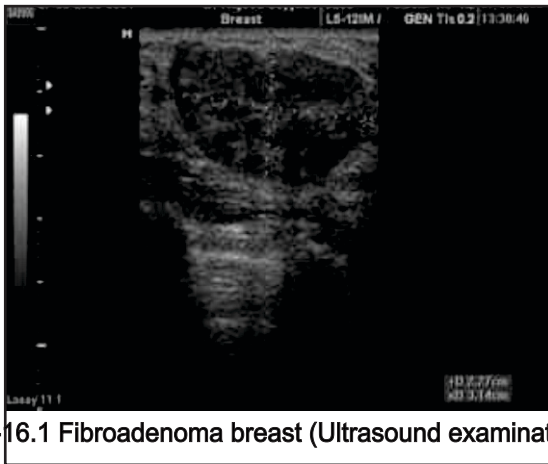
Fibroadenoma breast (Ultrasound examination)
